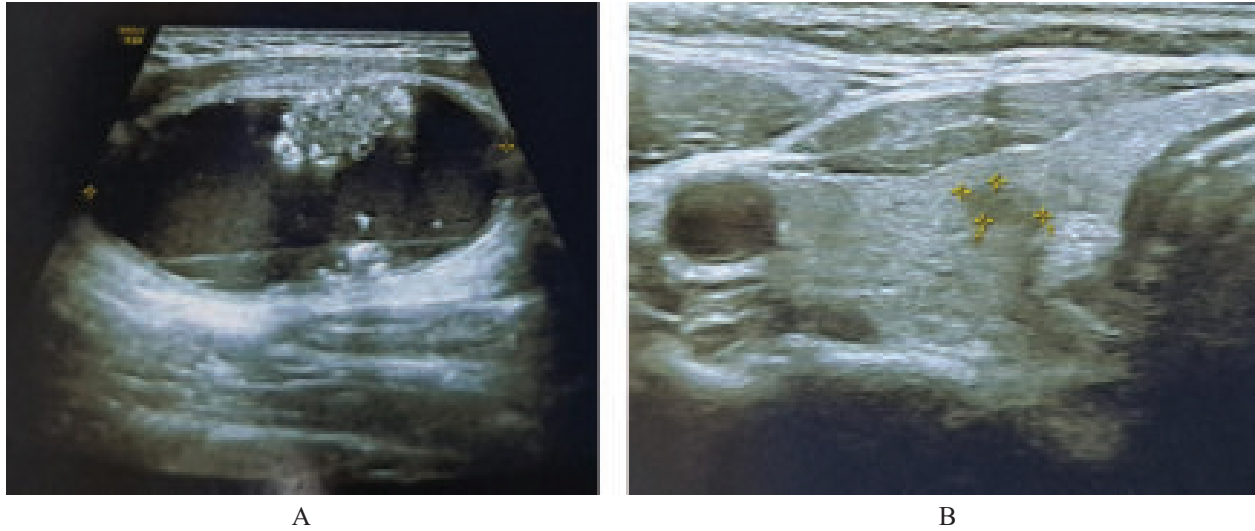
A. Neck ultrasound evaluation showed a) large cystic lesion (51x34mm) containing a solid component measuring about 18x10 mm at the right side of the neck, completely separated from thyroid gland b) small nodule (5.0x3.7mm) at right lobe of thyroid
